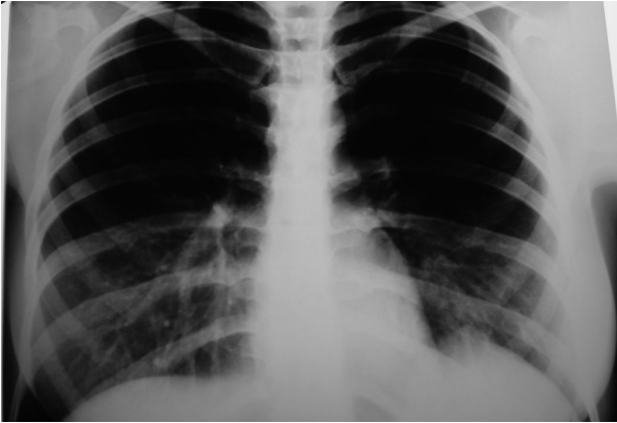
Roentgen image of the chest: the diaphragm border cannot be entirely seen, with a circular, well demarked shadow below left hemidiaphragm extending towards left hemithorax. Left phrenicocostal sinus is open.
